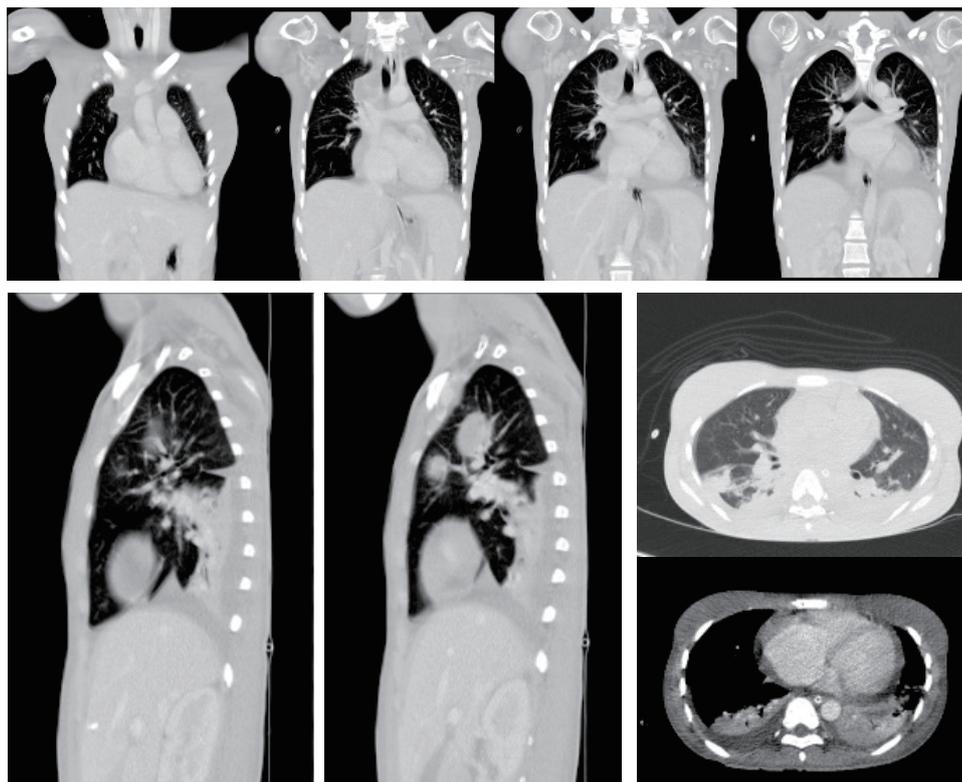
Chest CT Scan with IV contrast showed multiple lymphadenopathies in the mediastinum (around 2.4 cm), bilateral pleural effusion, partial atelectasis at bilateral inferior lobes, minimal ground glass opacity, and consolidation at bilateral posterodorsal, fibrosis at left lung (segment 5&9) and cardiomegaly accompanied with pericardial effusion
